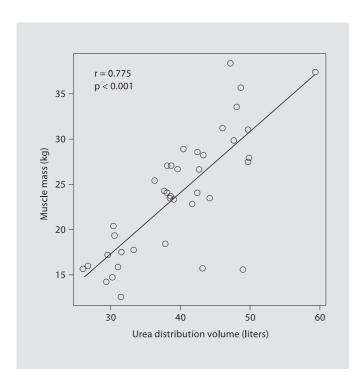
Muscle mass (estimated by whole body MRI) is positively correlated with urea distribution volume derived from urea kinetic modeling (for details of the methods applied see [17].
